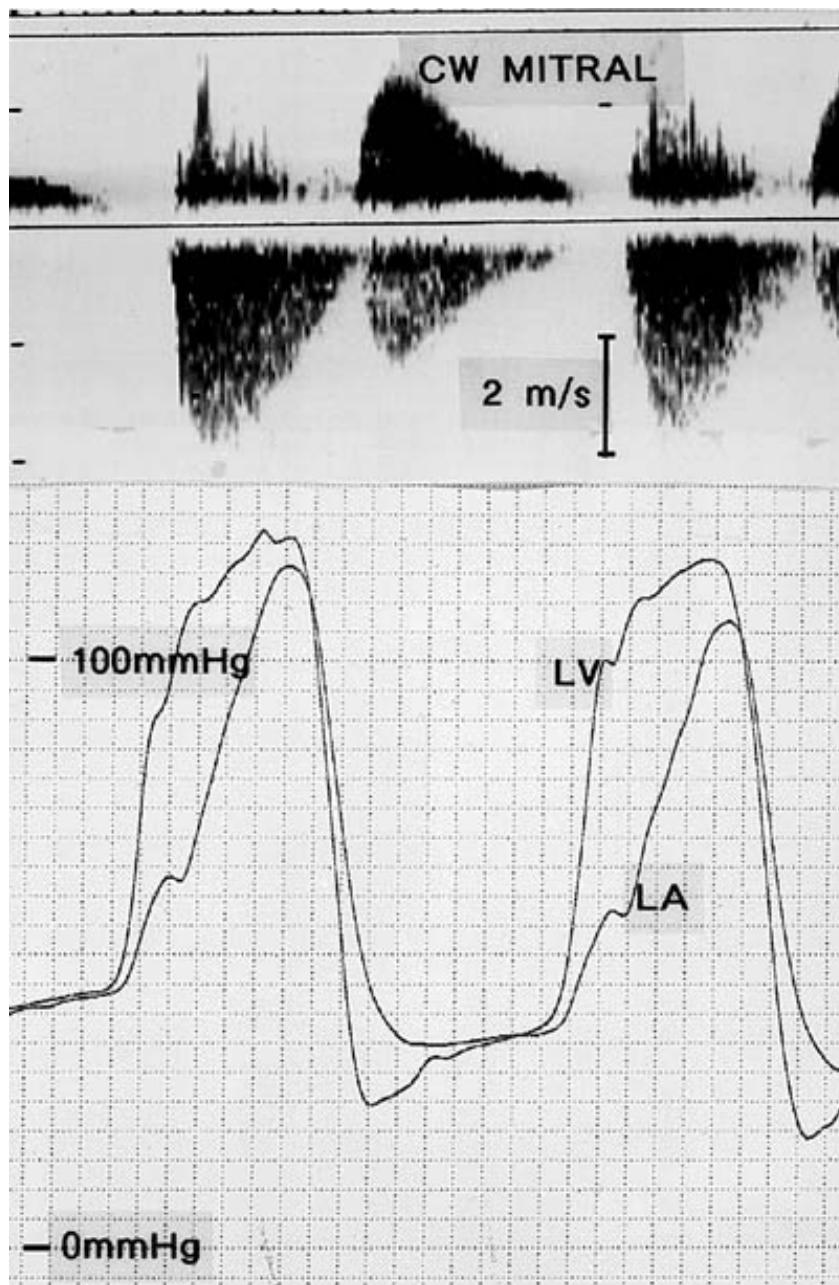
Simultaneous recording of LV and LA pressures and continuous-wave Doppler (CW) in a patient with severe MR. Note the large V wave on the left atrial pressure recording, with a triangular shape of the mitral regurgitant jet obtained by CW. (Courtesy of Dr. Rick Nishimura, Mayo Clinic.)
